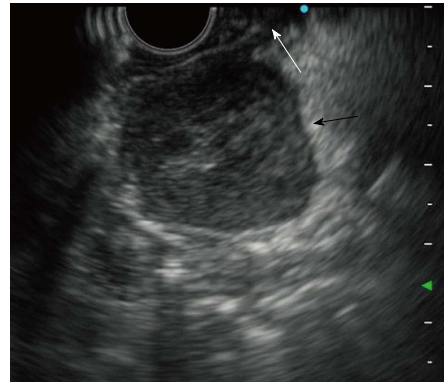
Endoscopic ultrasonography showed a well-defined hypoechoic mass in the pancreatic uncus, and the tumor connected with the muscularis propria layer of the duodenum. Black arrow indicates the tumor and white arrow indicates the muscularis propria layer.
